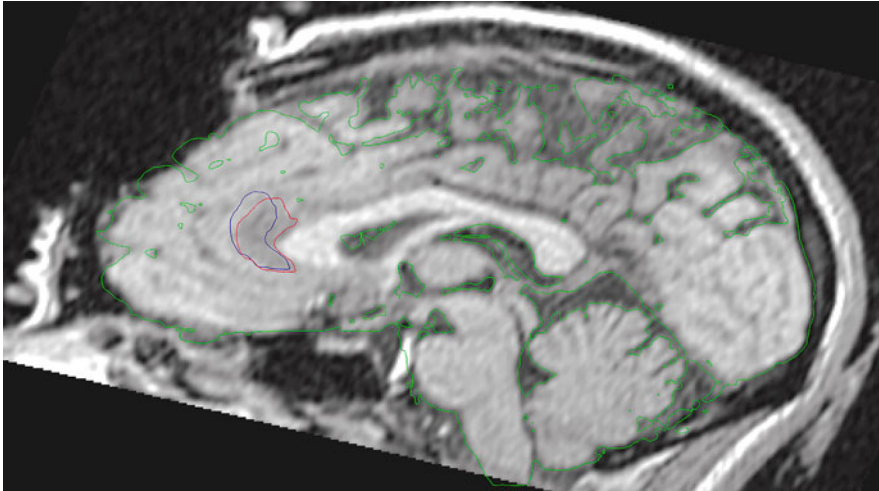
Comparison of the brain surface determined from images acquired pre-operatively (*green*) with the intra-operative images acquired after craniotomy. The pre-operative position of the tumor (*blue*) is shown against the intra-operative tumor segmentation (*red*). MRI images were provided by Department of Surgery, Brigham and Women's Hospital (Harvard Medical School, Boston, Massachusetts, USA)
